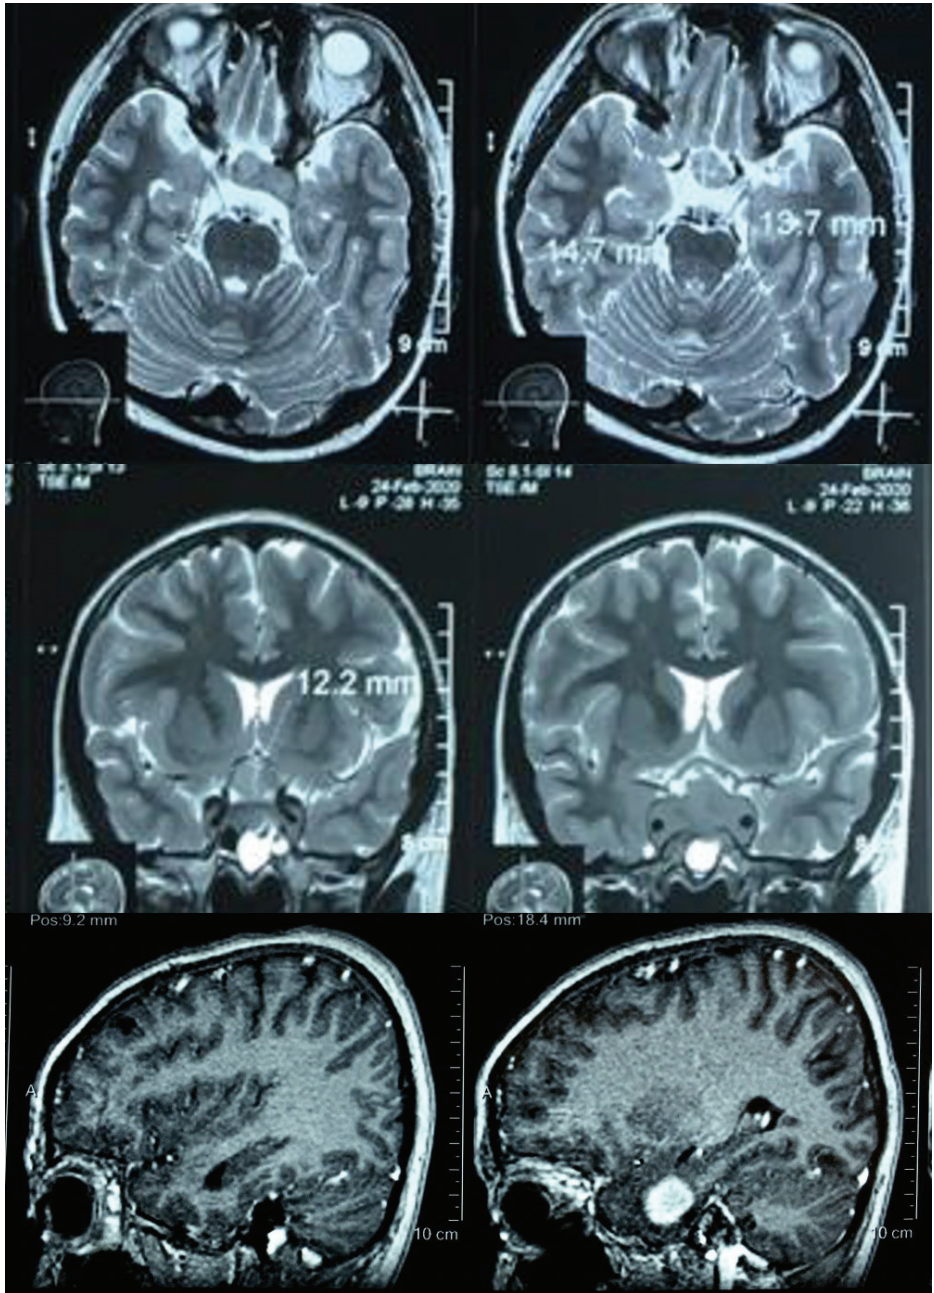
Magnetic resonance imaging showing a tumour mass in the sellar region compressing the optic chiasm.
